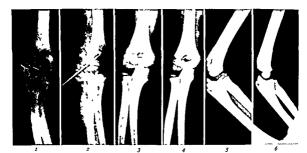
Fracture evulsion of the external episondyle and capitellum of the humerus of a boy of 7, 2043 r. 7 Retouched roentgenogram before reduction. 2 Open reduction and fraction of fragment with pin extending across the epophy seal line. The reduction was anatomically perfect but trauma to the cartilage from the initial injury, from open
